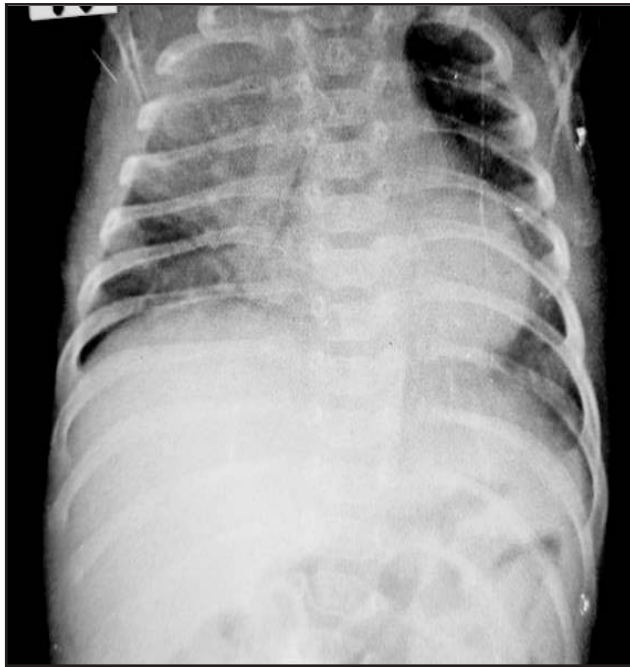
X-ray report at the age of 1 month-20 days
